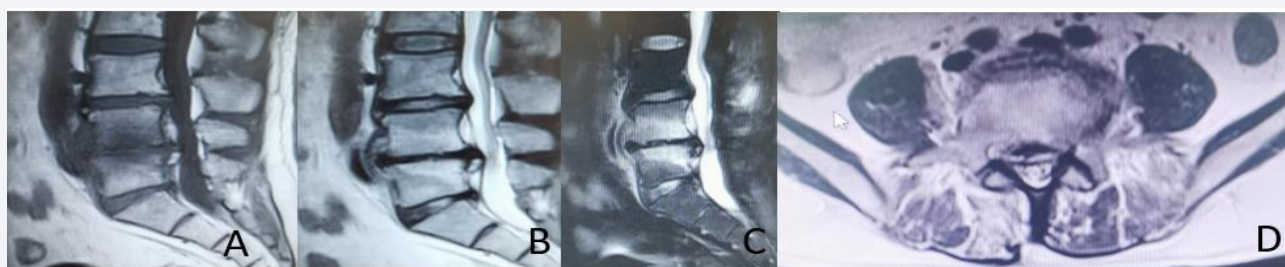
MRI examination of L4/L5 BS patients before operation. A showed that the signal of L4/L5 vertebral body and intervertebral disc was decreased and the bone of vertebral body was destroyed on T1-weighted imaging; B showed enhanced signal of L4/L5 vertebral body and intervertebral disc on T2-weighted imaging, and bone destruction of vertebral body; C showed that the signal of L4/L5 vertebral body and intervertebral disc was enhanced, and the abnormal strip shadow of L4/L5 anterior edge inflammation was detected by short time reversal recovery sequence technology; D shows the enhanced signal of L4/L5 intervertebral disc, inflammatory infiltration, and abnormal signal of L4/L5 anterior edge inflammation in cross section examination; BS is brucellosis spondylitis.
